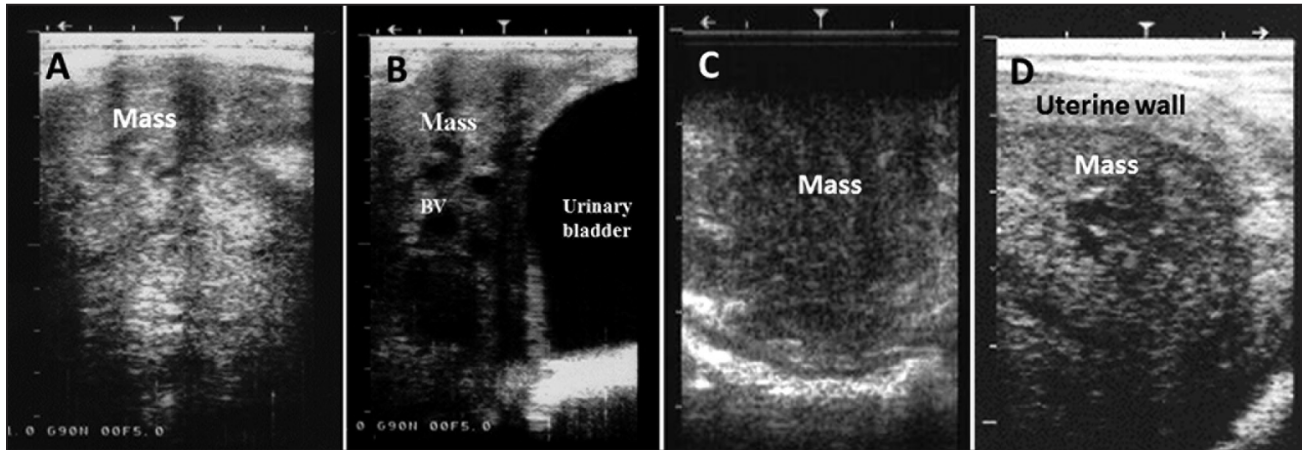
Sonogram of vaginal (A, B), cervical (C) and uterine (D) adenocarcinoma: the mass was echogenic, homogenous, mostly compact, but sometimes with enlarged blood vessels (BV).
